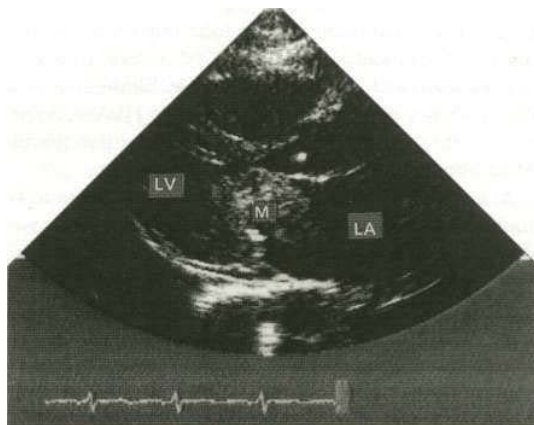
Atrial myxoma shown by a two-dimensional echocardiogram (long-axis view). The myxoma is an echo-dense mass obstructing the mitral valve orifice. It was removed surgically. LV, left ventricle; LA, left atrium; M, mass.
